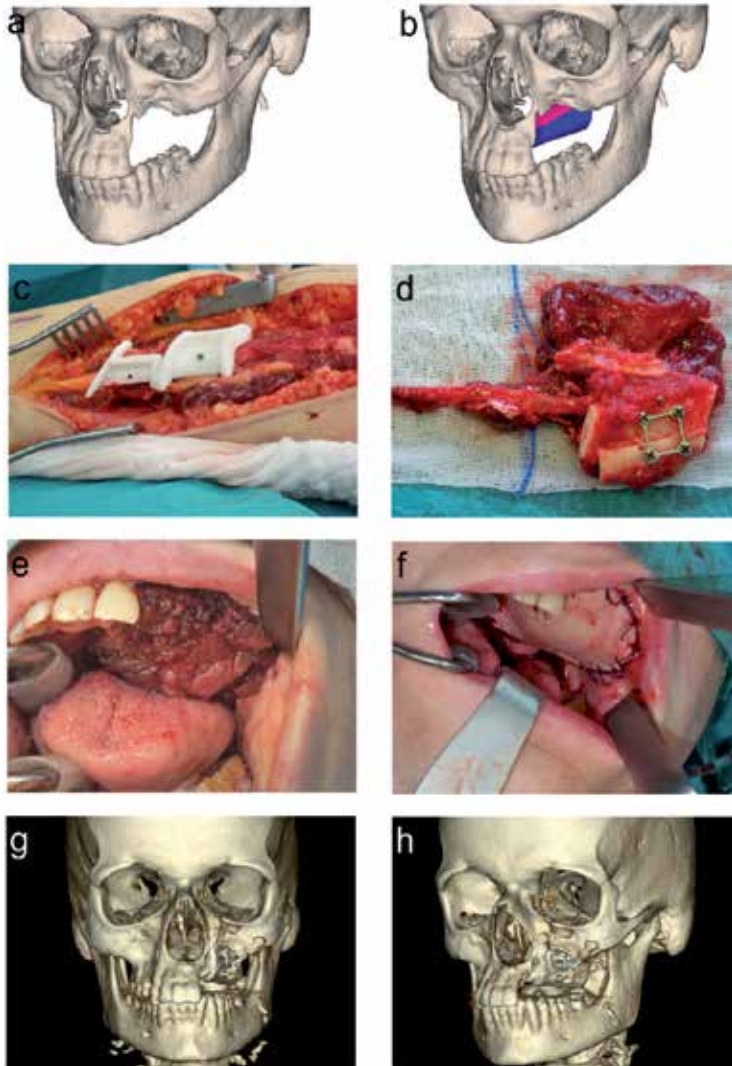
Case 4. (a) Initial finding of the maxillopalatine defect in the 3-D CT. (b) Virtual reconstruction with a double-barrelled fibula flap. (c) Positioning of the fibular cutting guide. (d) and (e) Prepared double-barrelled fibula flap inset into the defect area. (f) Inset of radial forearm flap for intraoral cutaneous covering. (g) and (h) Postoperative 3-D CT findings with incorporated fibula flap for osseous reconstruction.
